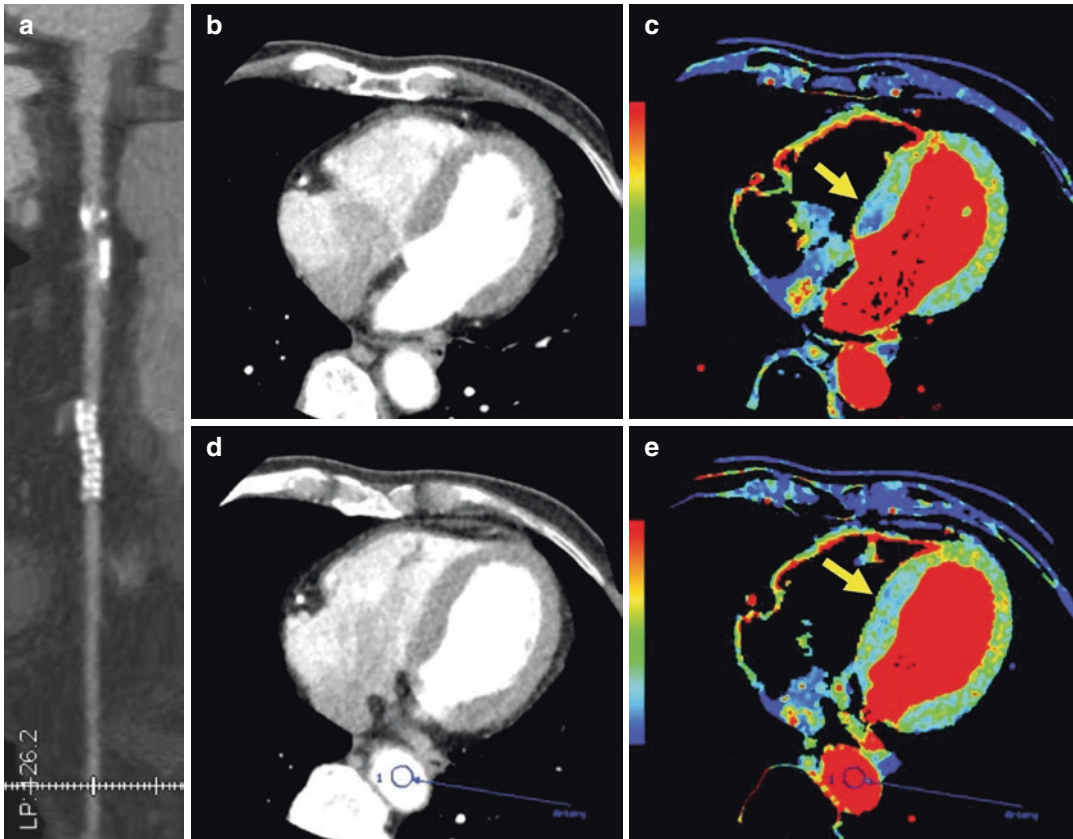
(a) Reformatted view of the left anterior descending artery (LAD). (b, d) Contrast-enhanced CT images in two axial slice locations acquired during maximal pharmacological stress with adenosine infusion. (c, e)
